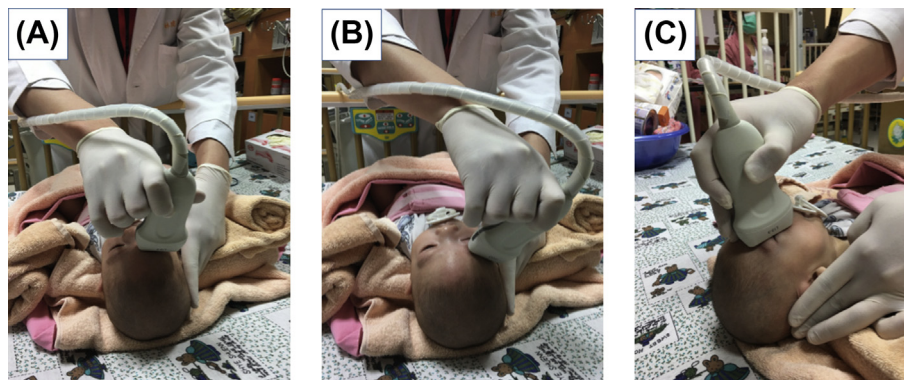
Technique for measuring sonographic optic nerve sheath diameter using an (A) anterior axis, (B) lateral axis, and (C) vertical axis transbulbar approach.
